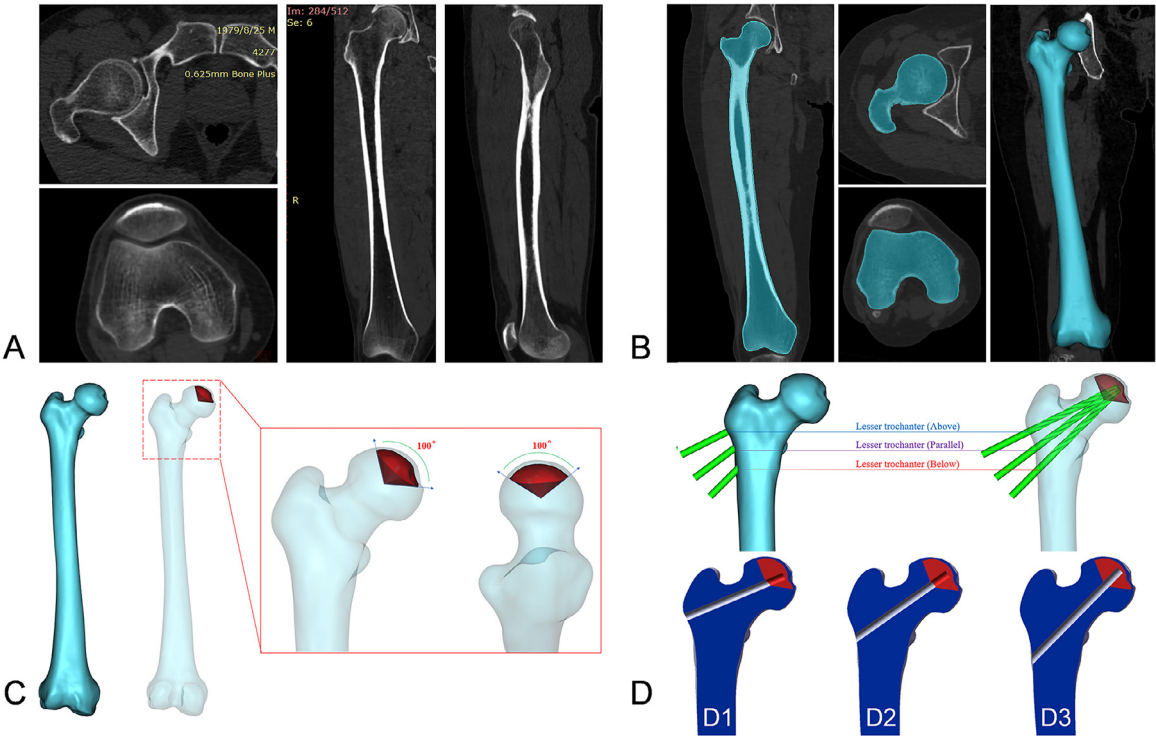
(A) Computed tomography (CT) images of patients; (B) Construction of 3D femur model; (C) Construction of the early ONFH; (D) Construction of different core decompression models: (D1) Lesser trochanter (Above), (D2) Lesser trochanter (Parallel), (D3) Lesser trochanter (Below).
